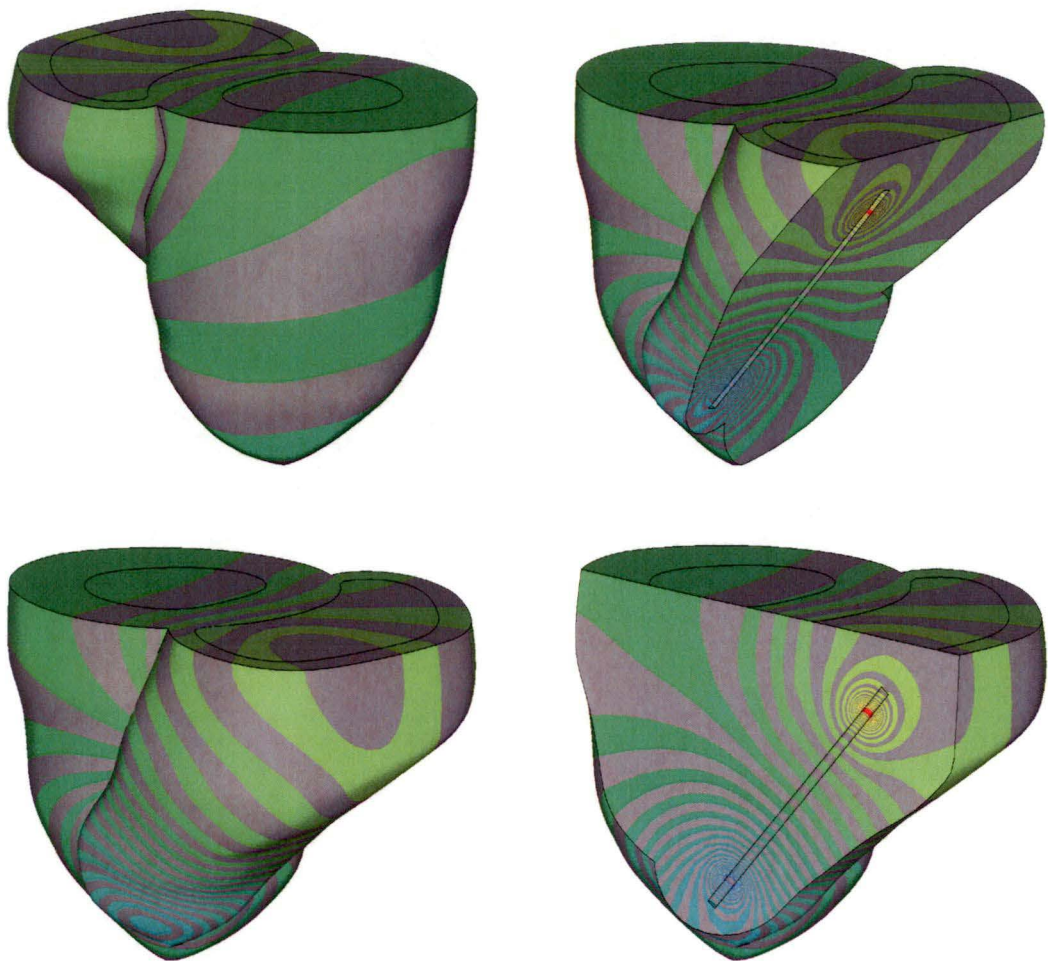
Right ventricle catheter voltage contours in tagged MRI model at end systole for blood conductivity/myocardium conductivity = 2.75.
